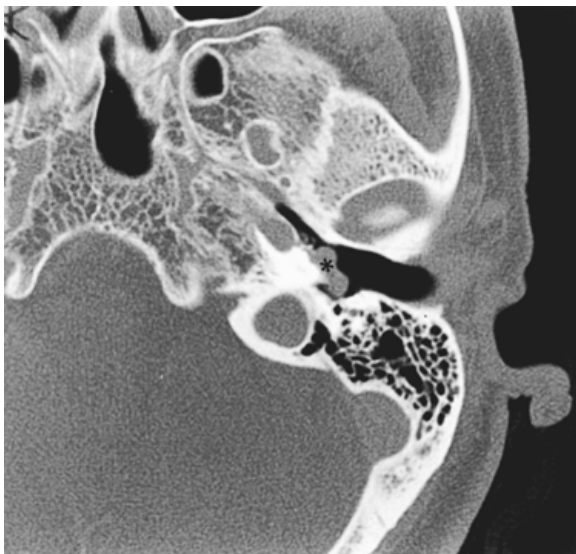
Glomus tympanicum, axial computed tomography. A bilobed, smooth, well-circumscribed mass is seen along the medial wall of the middle ear, in the hypotympanum (asterisk). The adjacent bone is intact.
